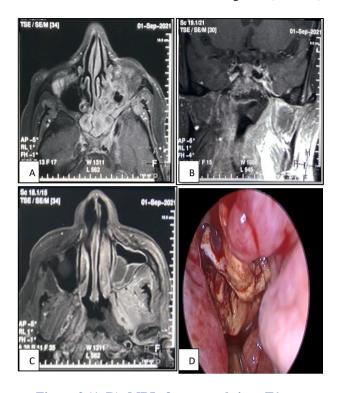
(A-D): MRI of paranasal sinus T1 post contrast axial section showing contrast enhancement in the turbinates, perisinus area, pterygopalatine fossa and infratemporal fossa, loss of contrast uptake in the left nasopharynx and fossa of Rosenmuller reaching till foramen lacerum area and till near the ICA and nasal endoscopy showing necrotic sloughed tissue over the sphenoethmoidal recess area, posterior to inferior turbinate and nasopharynx.
